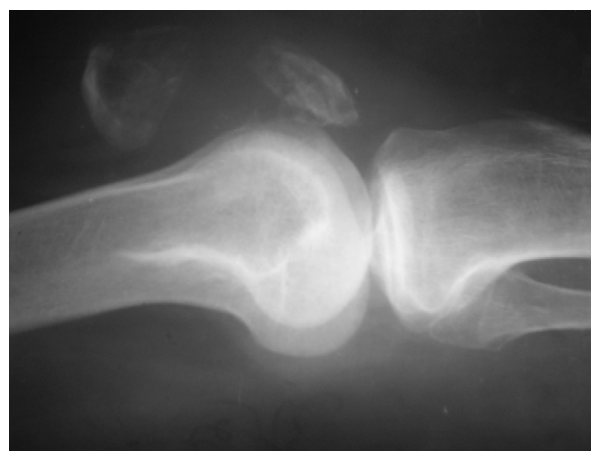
Preoperative radiograph of patella showing non-union (lateral view).
